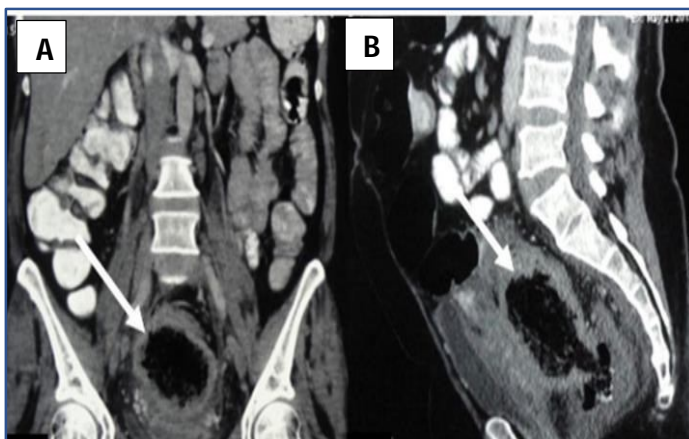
CT Abdomen and pelvis showed, well defined, heterogenous, air trapped pelvic mass
